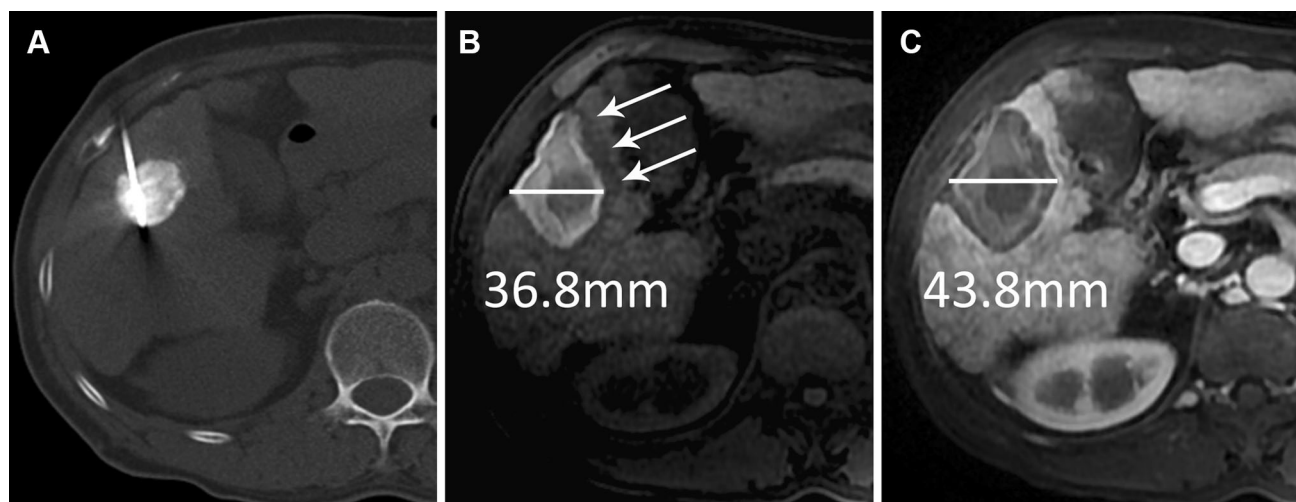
Magnetic resonance imaging (MRI) shows the ablation zone 37 h after tumor ablation. A Axial unenhanced computed tomography (CT) image obtained during microwave ablation (MWA) shows the microwave antenna in situ and the clear deposition of Lipiodol. B On the non-enhanced T1-weighted images obtained early after MWA, the ablated region has a characteristic hyperintense middle zone and a
